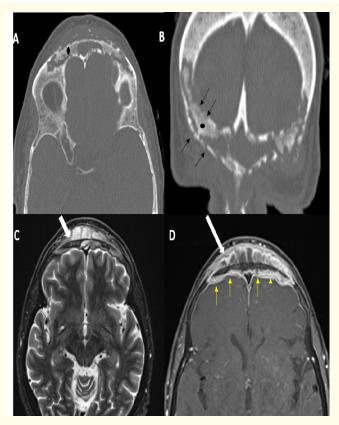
Figure 1A,B,C,D: Pre-operative CT and MRI of paranasal sinuses. Unenhanced axial and coronal CT from the frontal sinuses (A and B) shows complete opacification of frontal sinuses with destruction of the both inner and outer table of the sinus wall (Black arrows in B). Intrasinus contents show high-attenuation amorphous calcification/sequestrum (Black dot). Axial T2W MRI image (C.) shows complete opacification of frontal sinuses with the presence of T2 high-signal contents. Intrasinus T2 low signal intensity areas suggest sequestrum (small white arrow), which was seen on the corresponding CT images. A subperiosteal rim enhancing collection contiguous with the frontal sinus (long white arrow) keeping with Pott's puffy tumor. Frontal epidural pachymeningeal enhancement is also noted (Yellow arrows).
